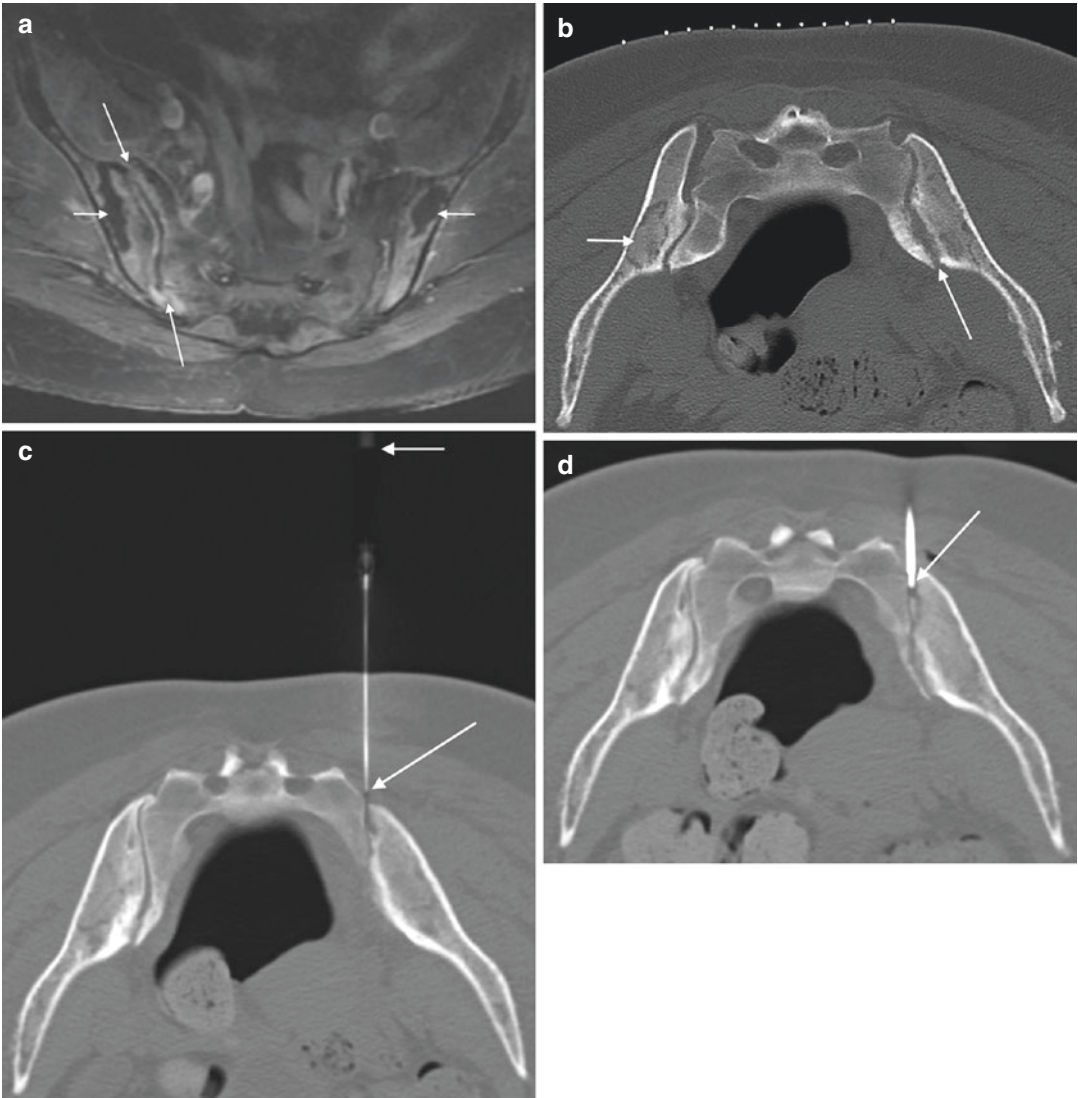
A 51-year-old female with lower low back pain. Fat-suppressed contrast-enhanced T1-weighted axial image (a) shows focal enhancement surrounding the right sacroiliac joint (*large arrows*) as well as iliac crest enhancement surrounding non-enhancing hypointense lesions (*small arrows*). Axial CT image (b) with skin grid in place shows an expanded sacroiliac joint with focal surrounding erosion (*large arrow*) and a sclerotic focus
